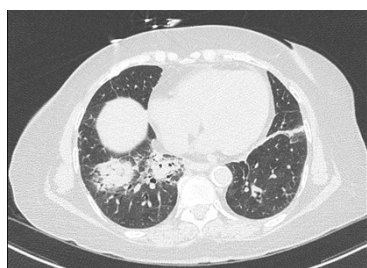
Axial CT showing consolidation with surrounding halo
